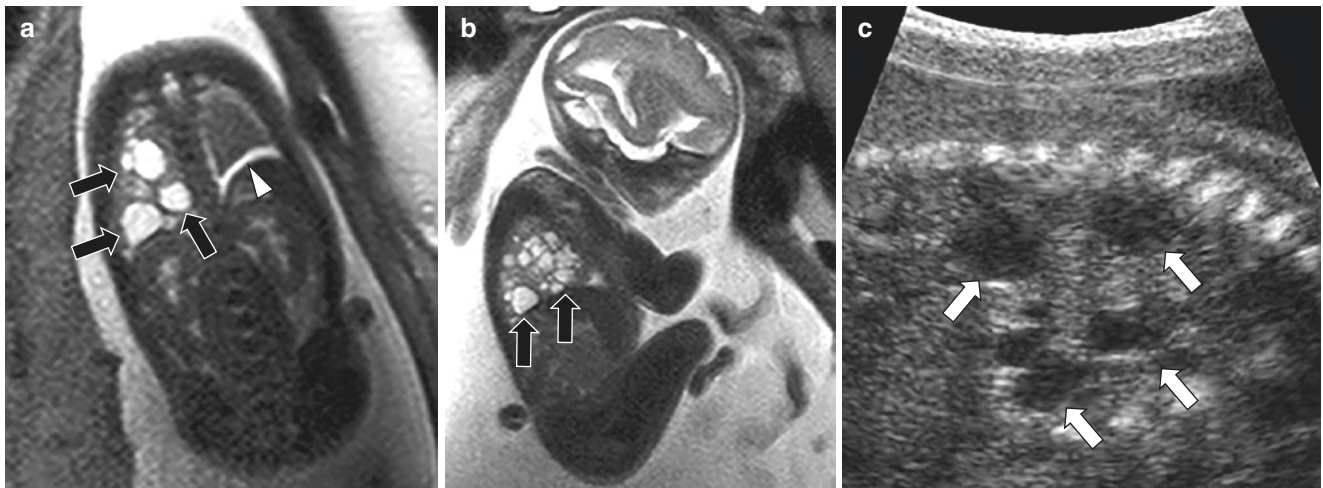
Macrocystic congenital pulmonary airway malformation (CPAM) on prenatal MR imaging. (a) Coronal non-enhanced T2-weighted MR image shows several hyperintense cysts (arrows) in the right lung. A left pleural effusion (arrowhead) is also present. (b)
